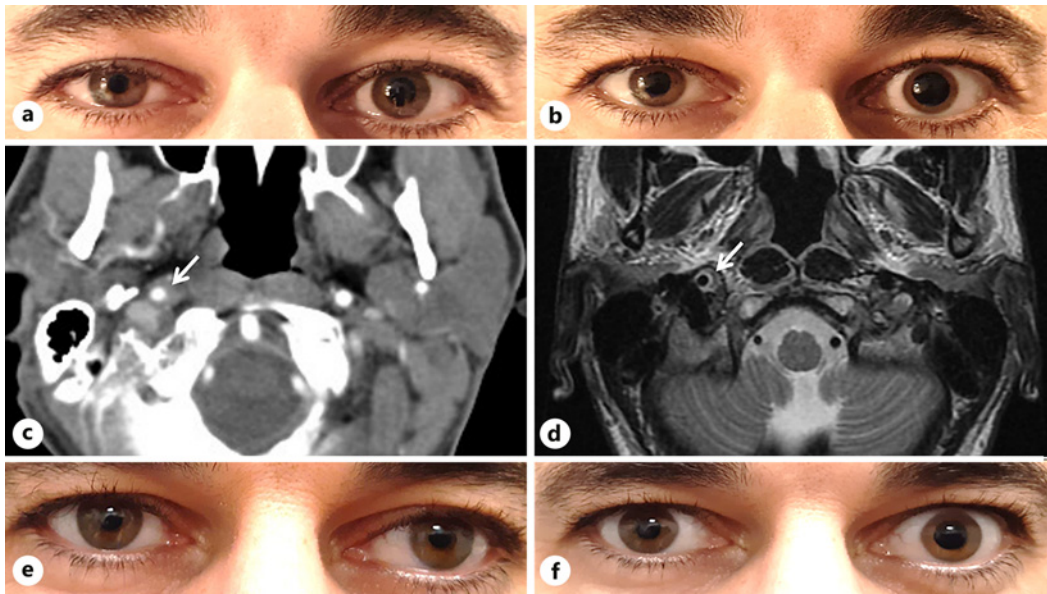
Photographs of patient 1 at presentation demonstrating Horner syndrome of the right eye with miosis and ptosis of the upper eyelid (a), followed by reversal of anisocoria and resolution of upper eyelid ptosis after instillation of topical apraclonidine 0.5% (b). Cerebral magnetic resonance angiography (c) and computed tomography angiography (d) demonstrating dissection of the right intrapetrous internal carotid artery (white arrows). Photographs at follow-up showing no more evidence of clinical (e) or subclinical (f) (using apraclonidine 0.5% pharmacologic testing) Horner syndrome.
